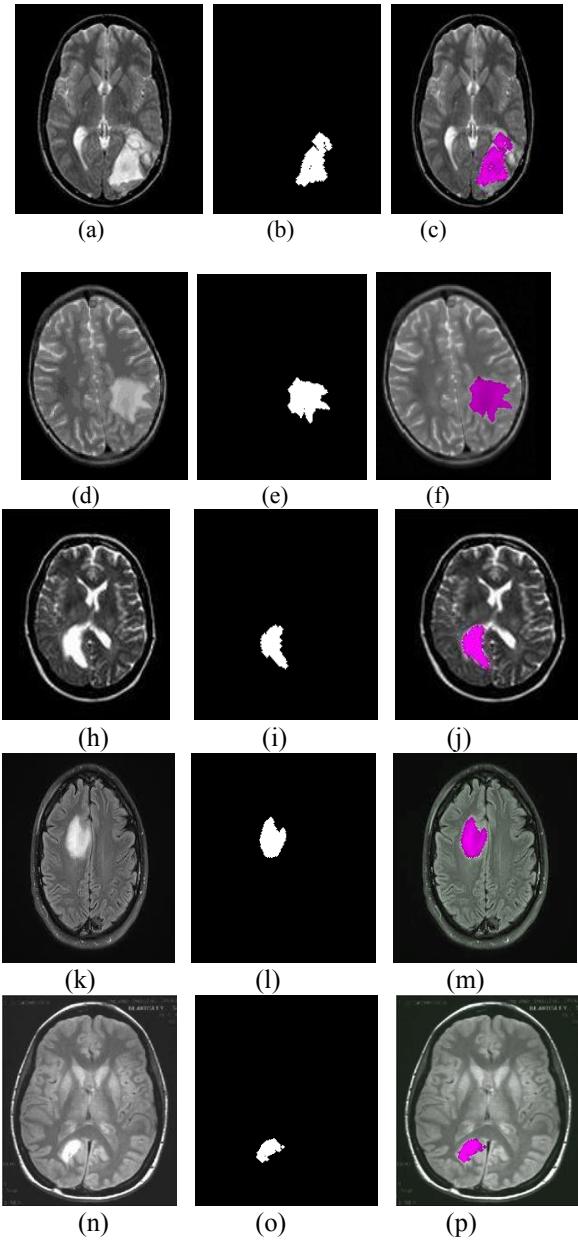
Output of the five different MRI images: (a), (d), (h), (k), (n) Original Image (b), (e), (i), (l), (o) extract tumor from original images using proposed method (c), (f), (j), (m), (p) shown the original image where tumor is situated.
